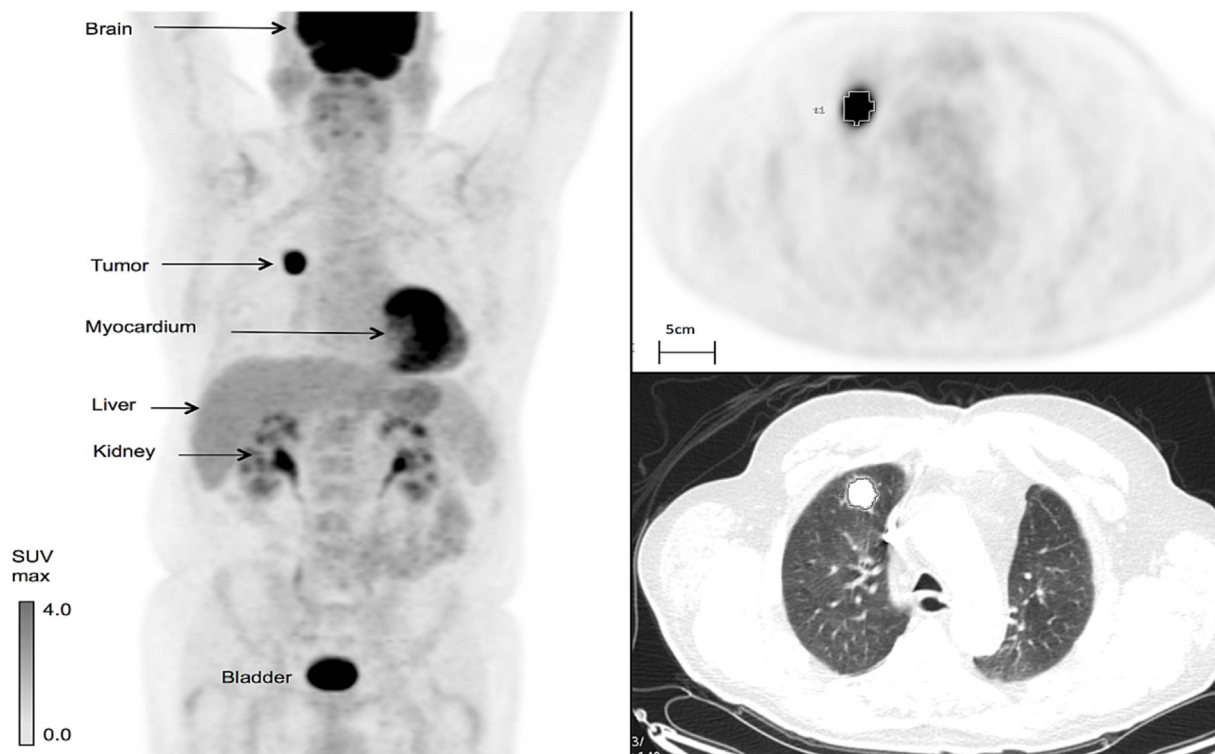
Left: Whole body intensity projection ^{18}F FDG PET/CT. Upper right: PET Image tumour uptake Lower Right: CT image (Nair et al., 2013).
